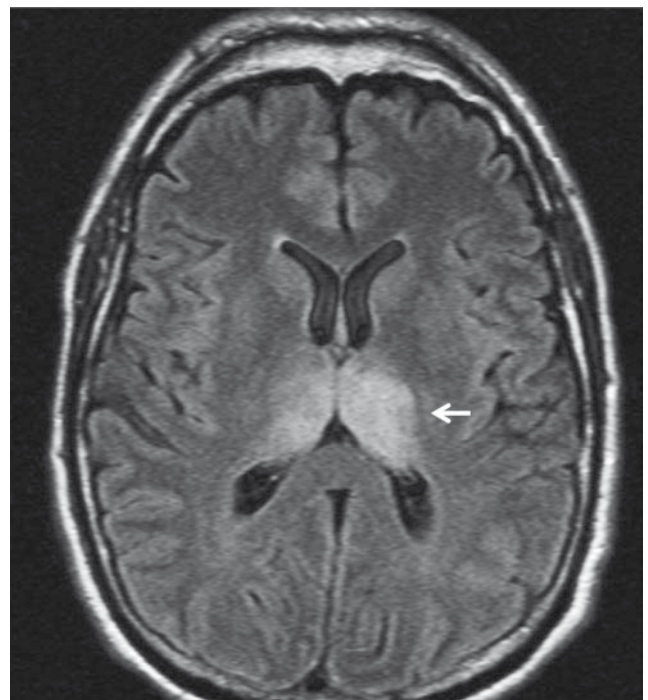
MRI brain scan of Murray Valley encephalitis 8 days after illness onset. FLAIR MRI scan demonstrating increased signal intensity in the thalami (arrow).
